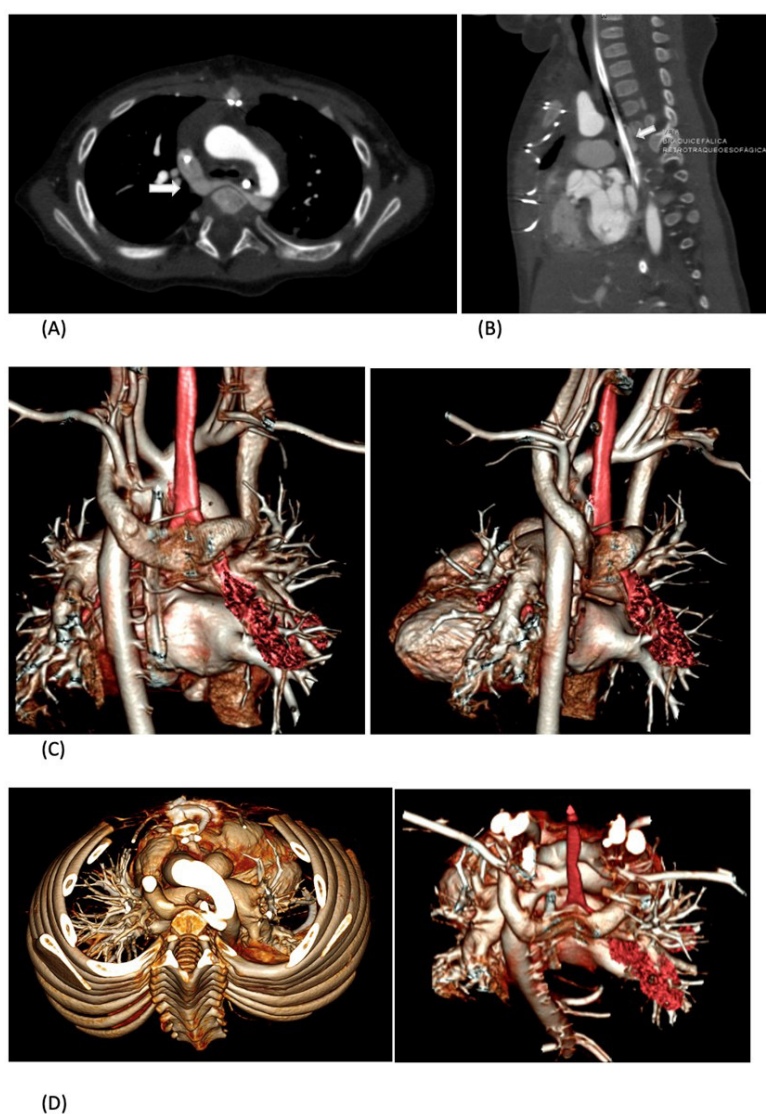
Contrast-enhanced computed tomography showing axial (A) and sagittal (B) images of the U-shaped retroesophageal course of left brachiocephalic vein (white arrow) which joins the right brachiocephalic vein to form the superior vena cava. Volume rendered image as seen from posterior aspect (C) and view from the top (D) shows abnormal course of left brachiocephalic vein into U-shaped vein. (red: trachea).
